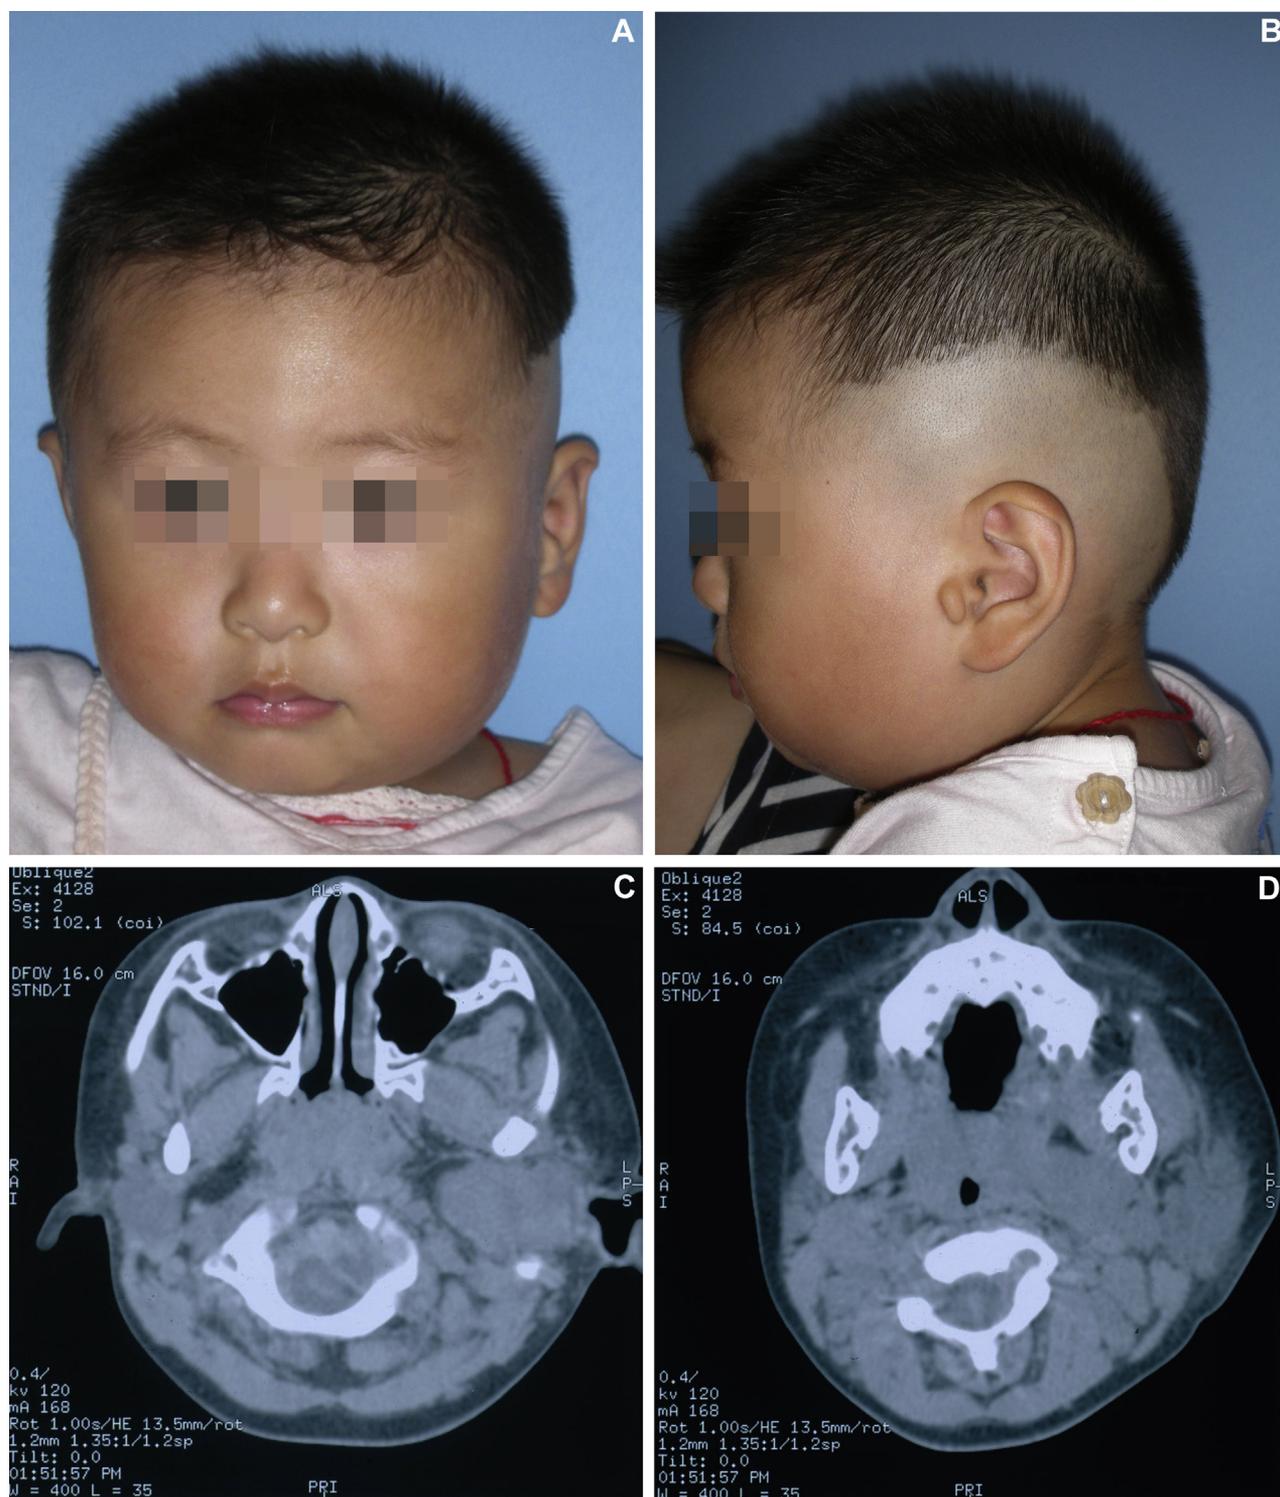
A, B, Photographs of the left parotid gland tumor before surgical treatment. C, D, Computed tomograms show the left parotid gland tumor before surgical treatment.
